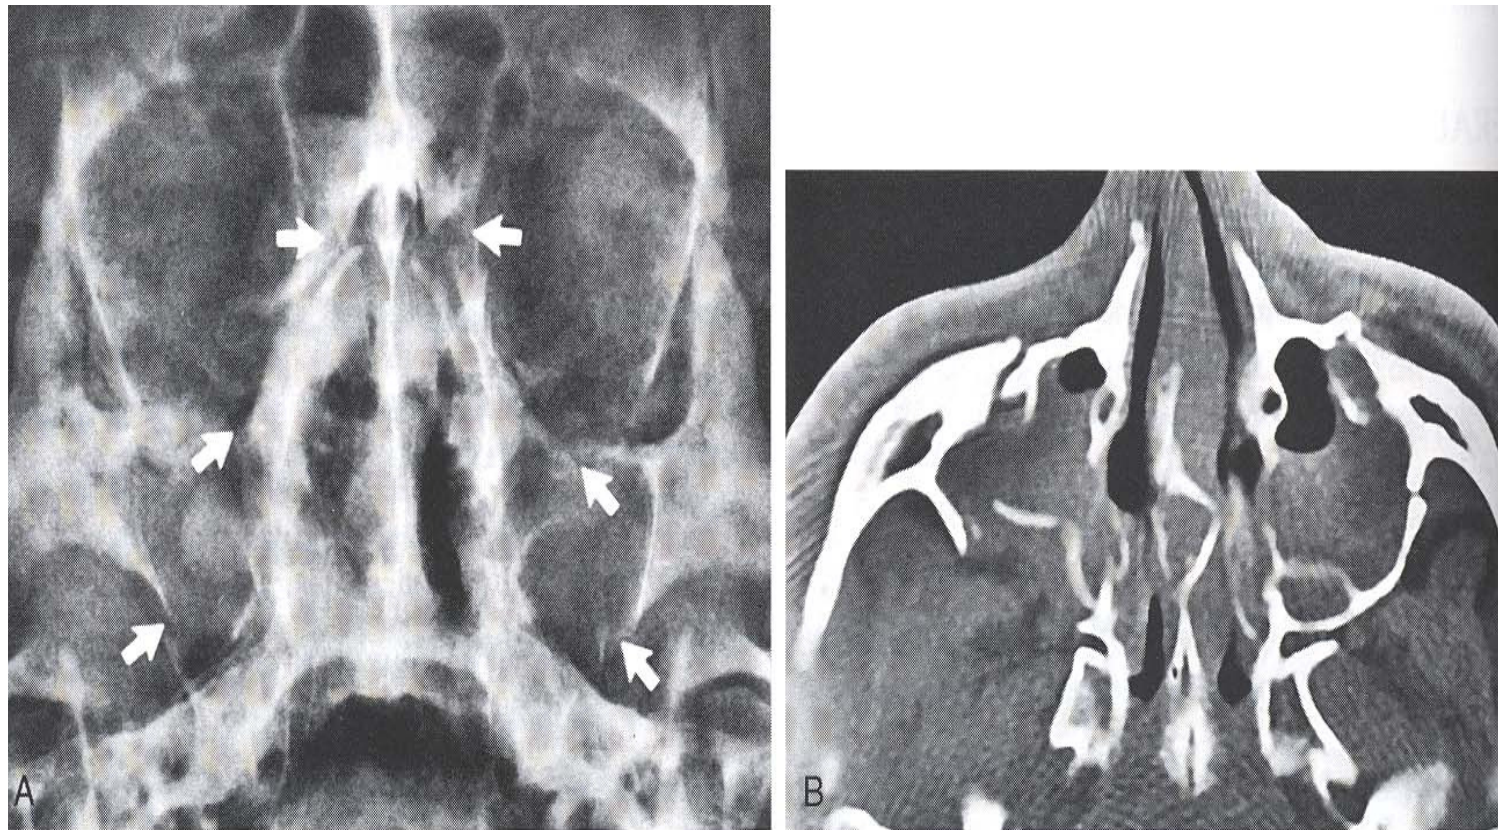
Waters view (A) shows a Le Fort II fracture (*arrows*) that creates a pyramid-shaped fracture segment. Axial CT scan (B) shows a Le Fort II fracture. The midface fracture segment is clearly seen, and the zygomas are uninvolved. On more caudal scans the pterygoid plates were fractured, and on more cranial scans the ethmoid sinuses and orbital floors were fractured.
